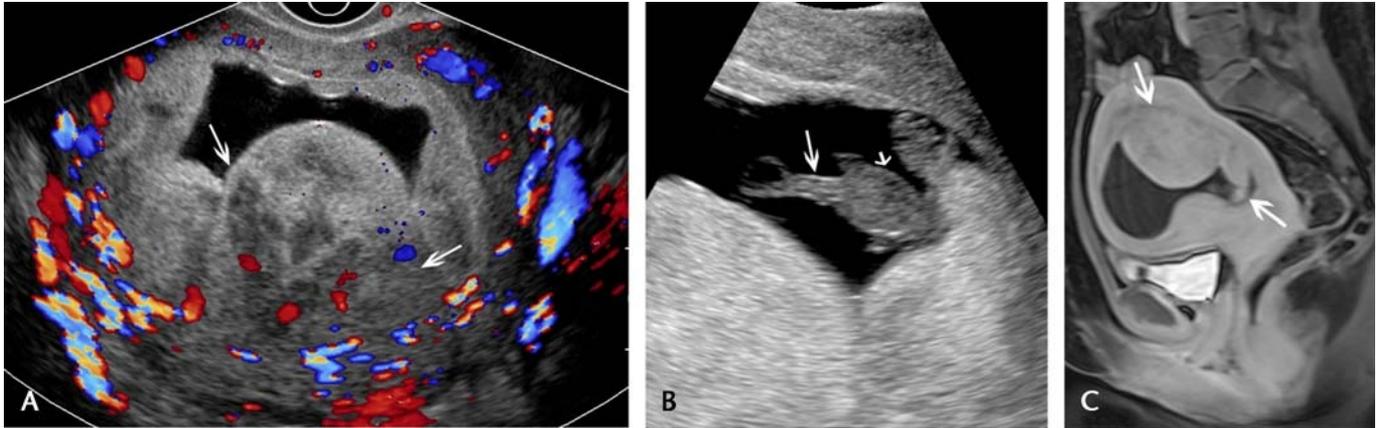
Partial hydatidiform mole. A 29-year-old woman with unknown last menstrual period was referred for assessment of fetal gestational age. A, Transverse Doppler ultrasound image of the uterus shows a heterogeneous solid and cystic vascular mass within the endometrial cavity (arrows). The uterine cavity also contains fluid. B, In addition to the vascular mass, fetal parts (small arrow), and a short umbilical cord (long arrow) were also identified. C, [Rev 3, com 15] On MRI, sagittal fat-suppressed T2-weighted image of the pelvis shows the heterogeneous mass within the uterine cavity (top arrow) and fetal parts (bottom arrow).
